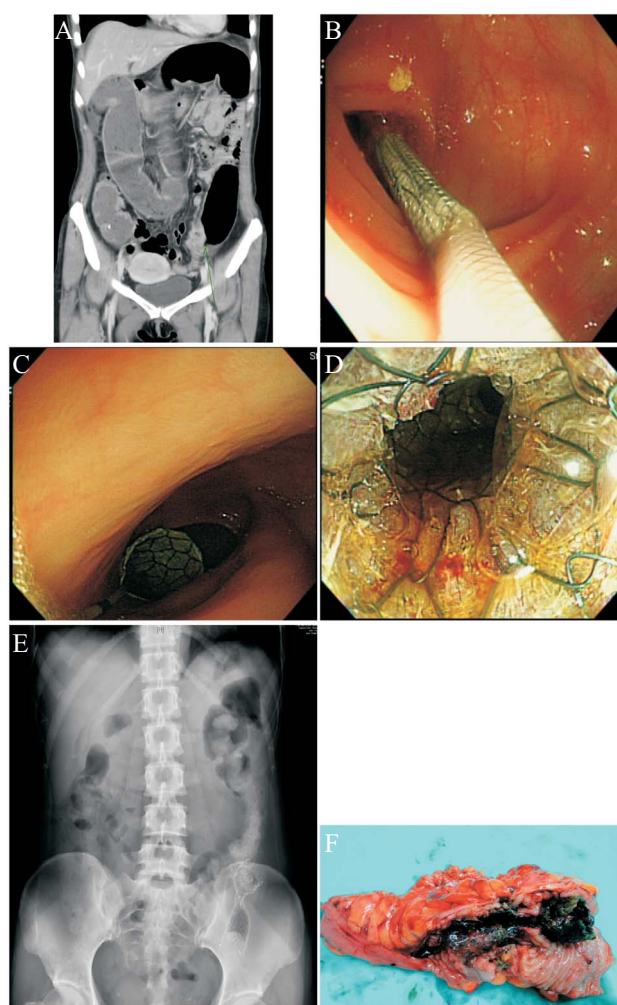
(a) Abdominal computed tomography image of a patient with a sigmoid colon tumor with obstruction before stent placement. (b) Cannulation of the stenotic segment using a guidewire. (c) The stent is placed through the channel of the endoscope and expands when in position. (d) Colonic decompression after stent placement. (e) Direct radiography after the procedure was completed. (f) Colon with stent after curative resection.
